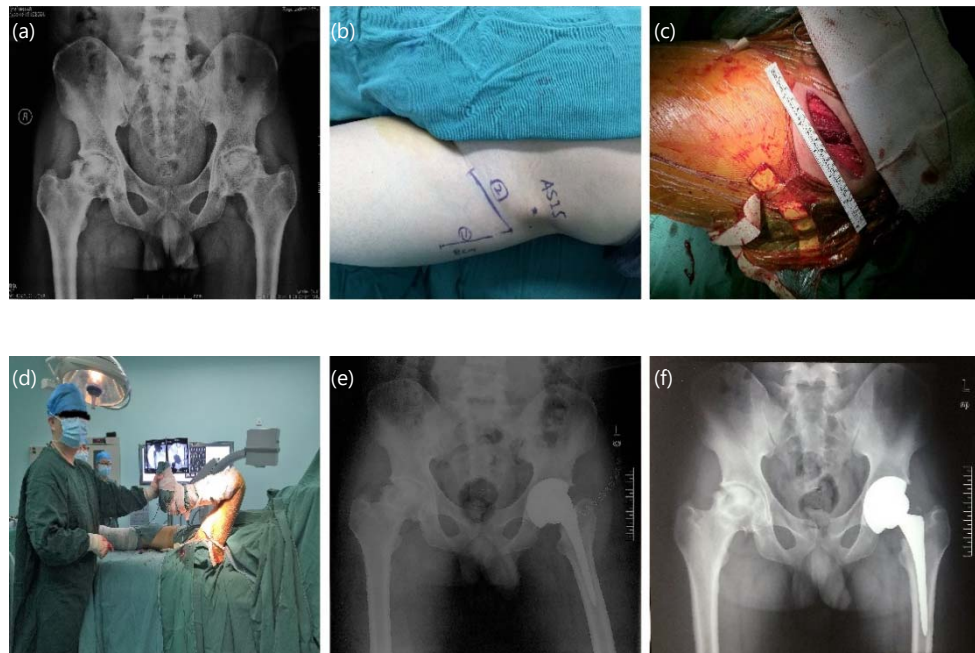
(a-f): Radiographs of a 78 years-old male patient with primary osteoarthritis of the left hip, (a) Before surgery, (b) Clinical photograph of the operative field seen before prepping and draping and demonstrating markings for the skin incision which is outline in relation to the anterior superior iliac spine (ASIS) and the tensor fascia lata (TFL), (c) Intraoperative photograph of the incised fascia of the TFL, (d) Intraoperatively range of hip motion testing, (e) Day-1 postoperative AP plain radiograph of pelvis with both the hip joints showing implant with no radiographic evidence of iatrogenic fracture and (f) 3-months postoperative AP plain radiograph after THA via DAA
